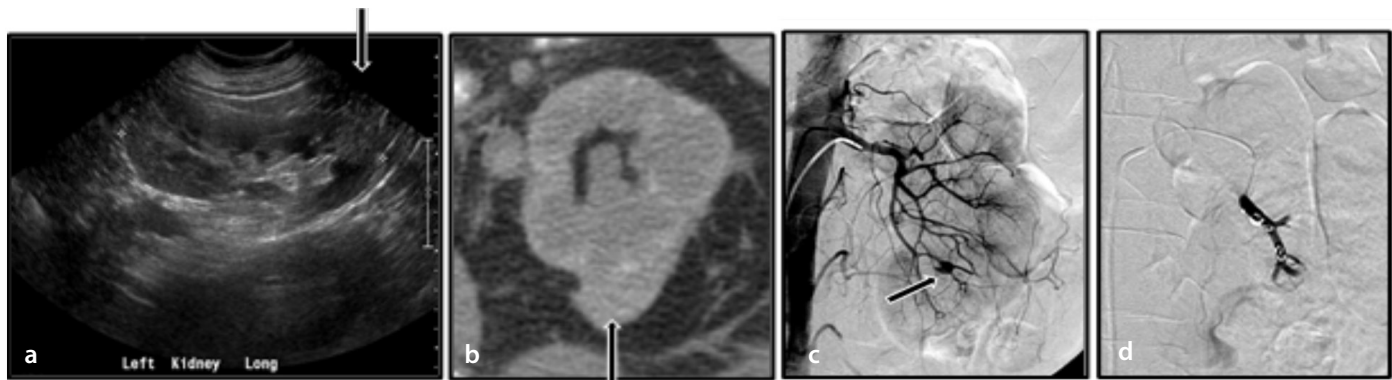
(a) A grayscale ultrasound of the left kidney after a non-targeted renal biopsy demonstrates a hyperechoic mass-like area in the left kidney lower pole (black arrow). (b) An axial non-contrast CT confirms a small subcapsular hematoma (black arrow). (c, d) A digital subtraction angiography of the left kidney demonstrates a small pseudoaneurysm (black arrow in c), which was subsequently embolized (d). CT, computed tomography.
